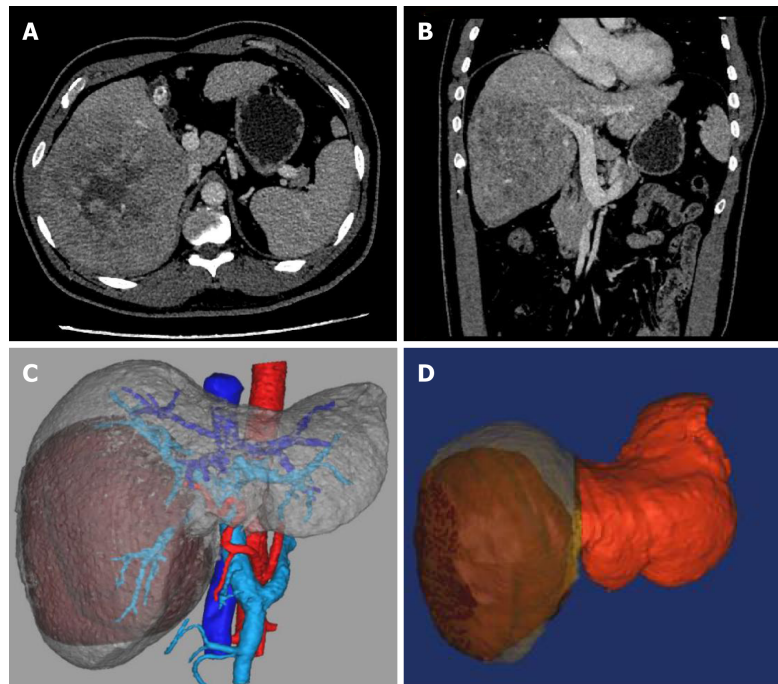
Preoperative computed tomography images and 3D reconstruction. A and B: Computed tomography (CT) transverse (A) and coronal (B) images before operation; C: 3D image showing the relationship between tumor, blood vessels, and the bile ducts; D: 3D image (red color for residual liver, gray color for tumor).
